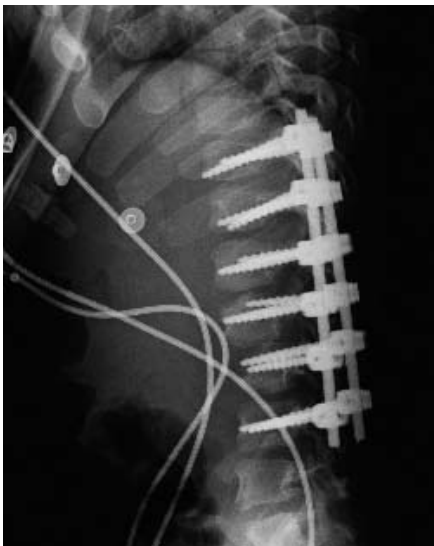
Post-op radiography.
